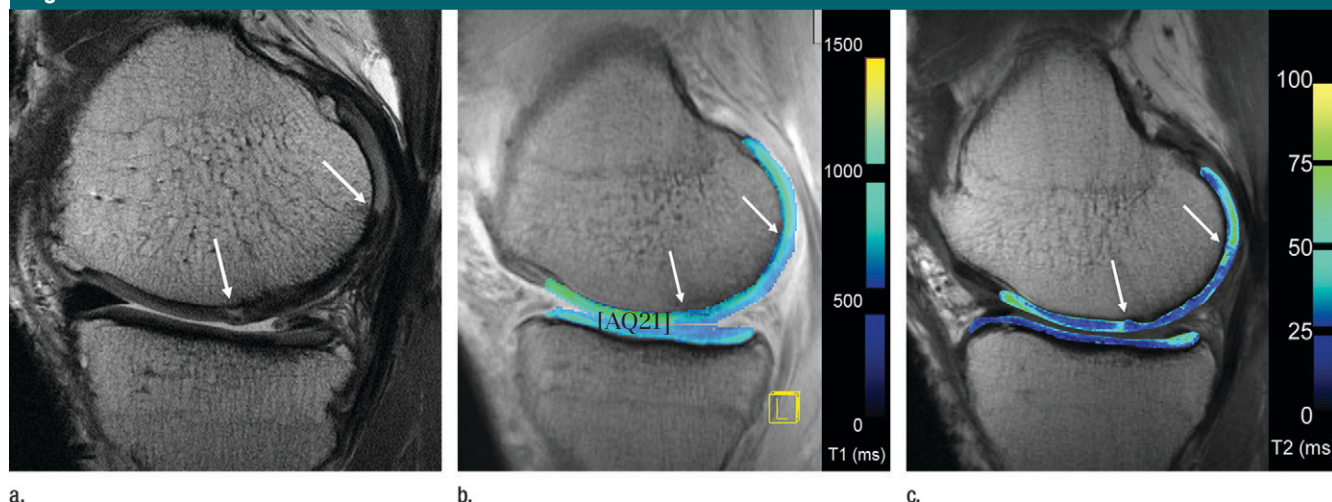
Sagittal MR images of cartilage repair. Arrows = anterior and posterior margins of transplant. (a) Proton density-weighted high-spatial-resolution image (3200/30) of medial tibiofemoral compartment 4 years after matrix-associated fibrin-gel-based autologous chondrocyte transplantation. Complete filling of femoral cartilage defect with complete peripheral and central integration to adjacent cartilage and subchondral bone. Surface of the transplant is smooth and the structure is homogeneous. Signal intensity is markedly lower than that of normal hyaline cartilage. (b) Corresponding contrast-enhanced T1 map (dGEMRIC, 490/13) shows homogeneously lower T1 values in cartilage transplant, as compared with normal hyaline cartilage (blue). (c) Corresponding T2 map (2700/10–70; flip angle, 180°) shows comparable T2 values in cartilage transplant region, as compared with those of normal hyaline cartilage.
